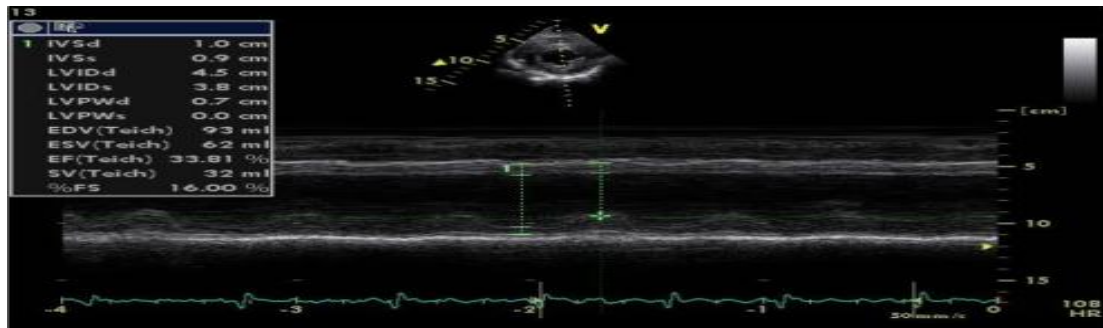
Measurement of LV systolic function using M-mode in the parasternal short view
